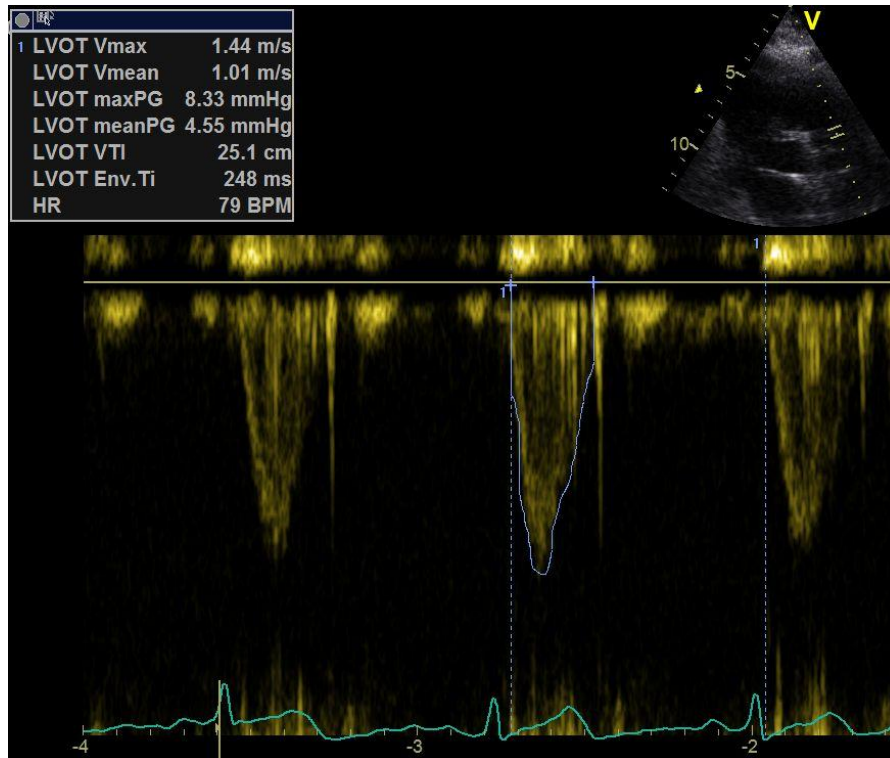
Pulsed wave Doppler trace through the left ventricular outflow tract trace from apical four chamber view. The first view: 2D image of apical four chamber view which shows the sample volume at aortic outflow tract; second picture: pulsed wave Doppler trace of velocity time integral.
